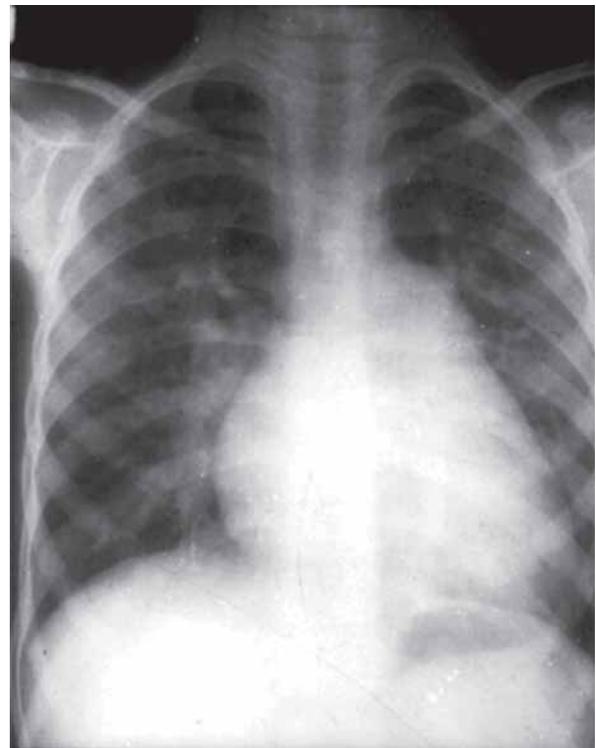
Chest radiograph showing cardiomegaly, prominent pulmonary artery segment and increased pulmonary blood flow in a case of large VSD
